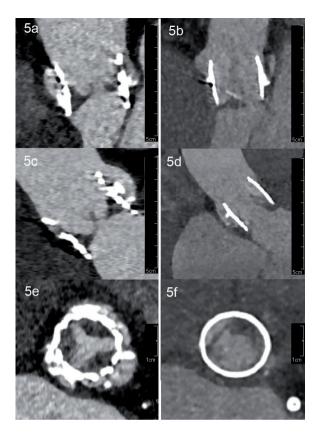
CTA images of a Sapiens valve with signs of leaflet thrombosis (5a,c,e) and a Lotus valve with signs of vegetation (5b,d,f).
